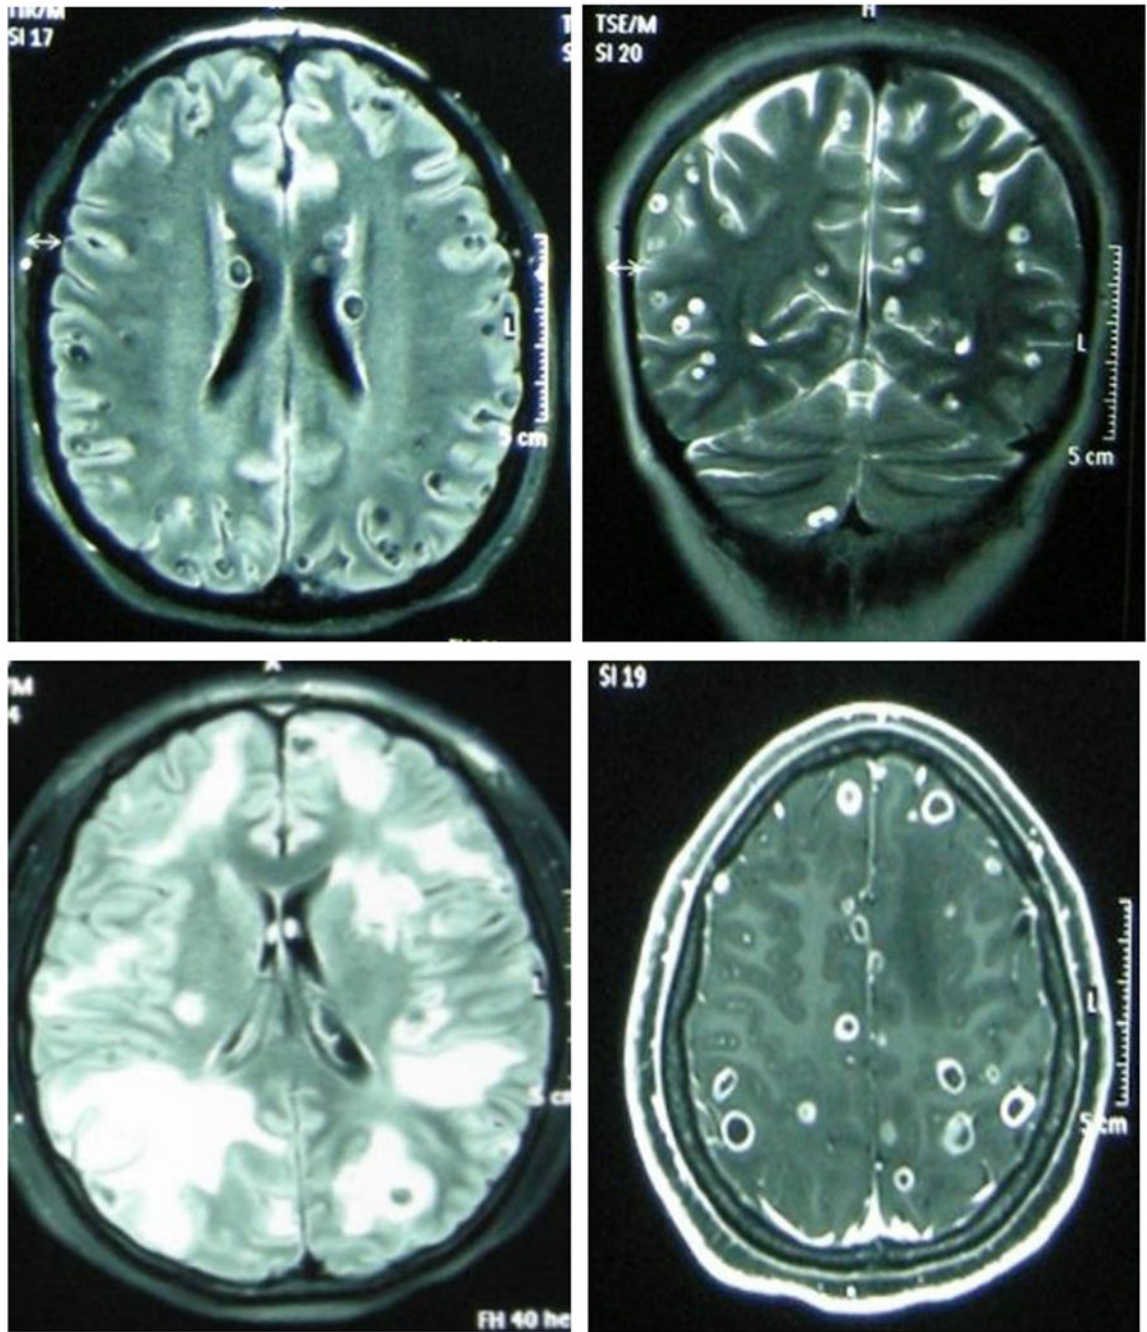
Massive parenchymal NCC, non-encephalitic (above, FLAIR and T2 MRI protocols) and encephalitic (below, FLAIR and post-contrast T1)
